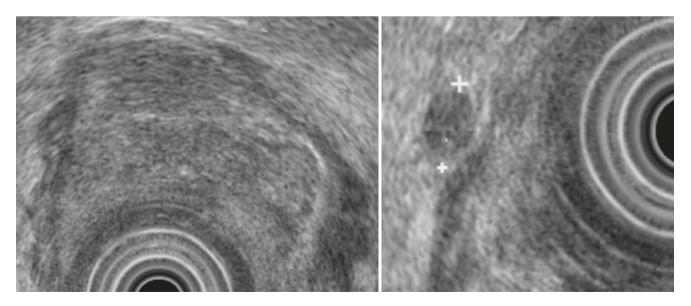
Endorectal ultrasound of T3N1 tumor. (Courtesy of Lehel Somogyi, MD)
